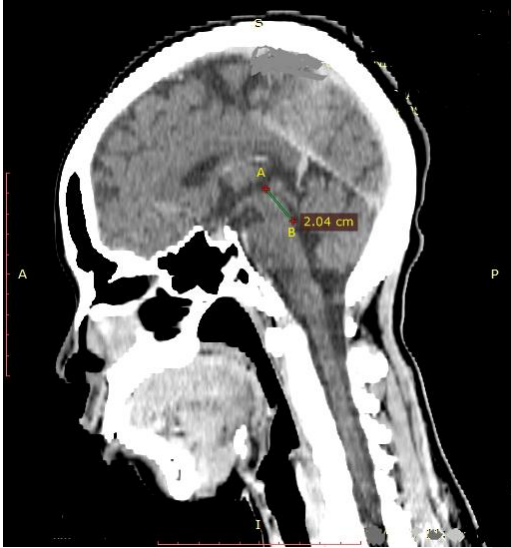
A CT image showing measurement of the anterior-posterior diameter (A-B) of cerebral aqueduct.
